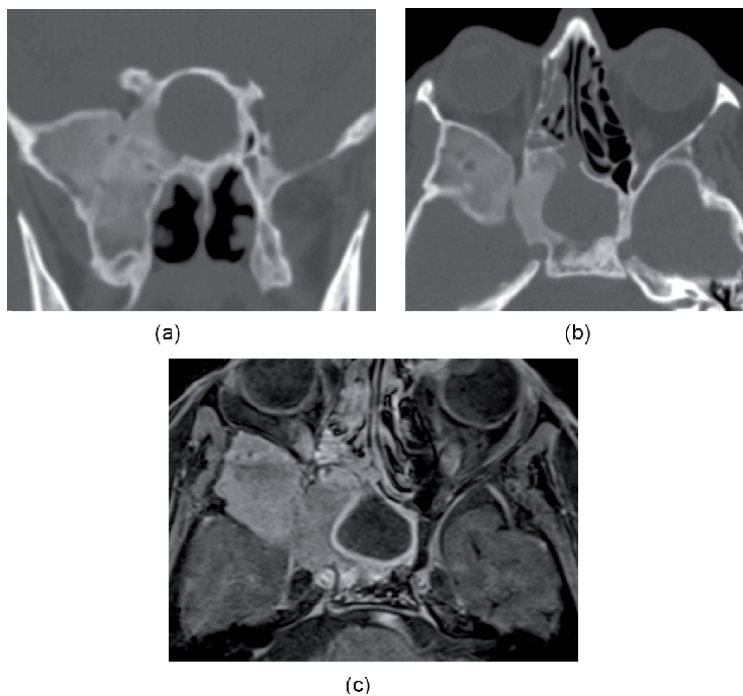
(a) Coronal CT and (b) axial CT demonstrate fibrous dysplasia, in the right sphenoid bone. The bone has characteristic “ground glass” appearance and encircles the foramen rotundum and the Vidian canal. In addition, the sphenothmoid recess is obstructed and mucus entrapped in the right sphenoid sinus, with bowing of the sinus walls typical for mucocoele and pyocoele. (c) Axial MRI with T1 with gadolinium shows contrast medium enhancement limited to the mucosal lining. The low signal in the sinus is consistent with a mucocoele.
